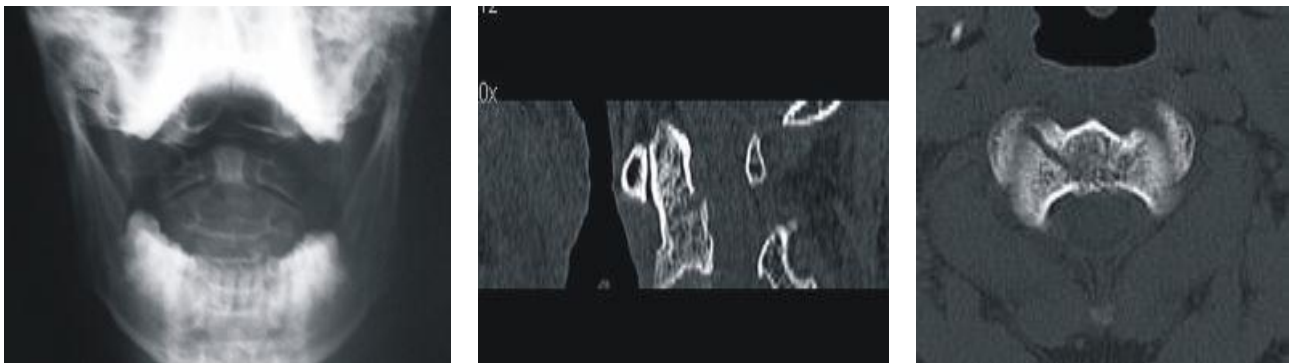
Radiograph open mouth view (5a) showing type II dens fracture. In same patient, CT cervical spine sagittal (5b) and axial view (5c) revealing type III dens fracture.
